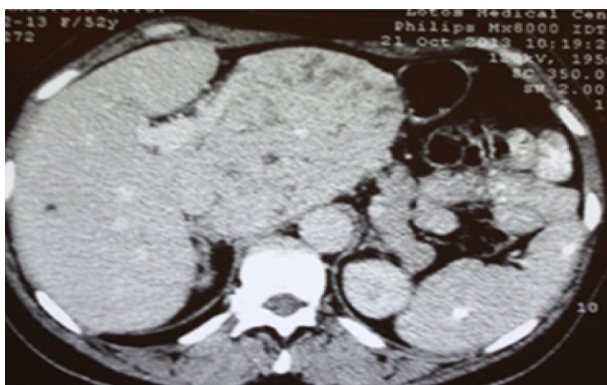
Abdominal computed tomography with contrast enhancement: Tumor invades segment I of the liver (longitudinal section). Ill-defined contrast-enhancing, multilobulated cystic lesion involving segments II, III, VI and VIII.
